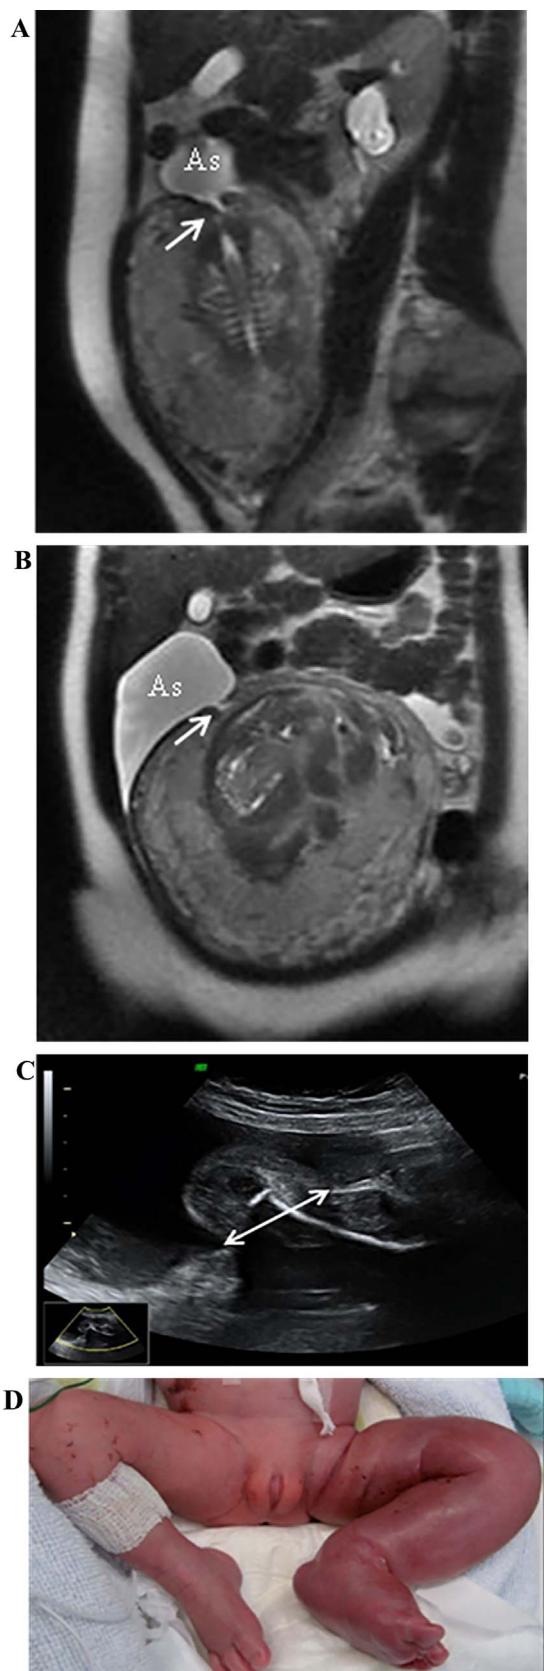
Stable uterine rupture. 27 y.o. patient with antecedents of iatrogenic uterine rupture at laparotomy. Sagittal and coronal (a, b) T2-W MR images at the 29th week of pregnancy revealed a focal uterine rupture in the right uterine fundus wall, at the level of the old uterine scar, with prolapsed amniotic sac (As). The patient was treated conservatively with bed rest, i.v. tocolysis and fetal lung maturation. US control at 32th pregnancy week (c) shows increased rupture of the uterine wall (double white arrow), with a leg of the fetus now extending through it. Diagnosis was confirmed at cesarean delivery. After birth, the left leg presented edema and deep furrows at the upper thigh (d).
